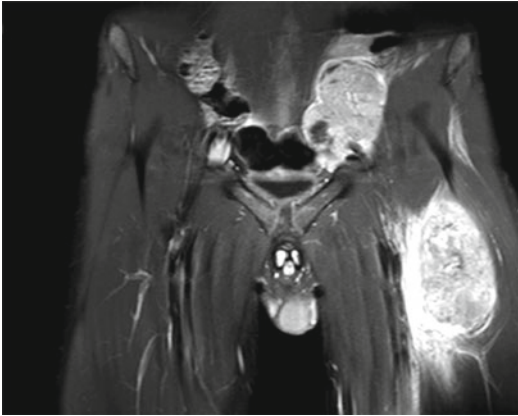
Magnetic resonance imaging of a 16-year-old boy with a malignant peripheral nerve sheath tumor (MPNST) of the thigh, with regional lymph nodal involvement
